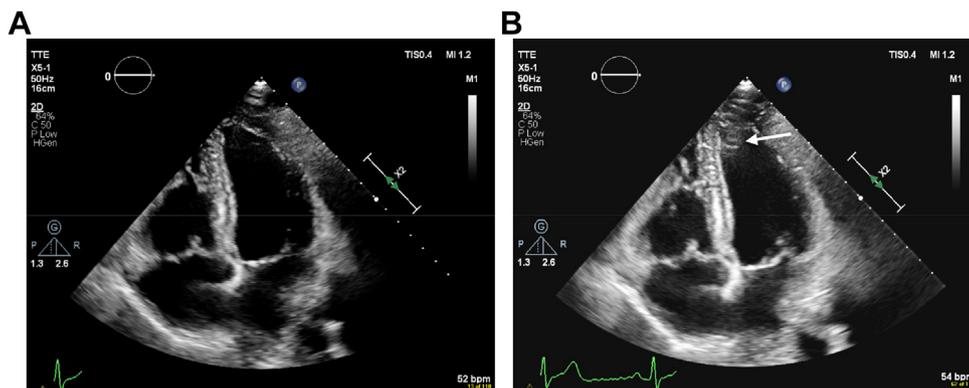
Generation of NFC in a healthy individual. In panel A, a standard apical four-chamber view is shown with clear visualization of the LV apical region without any artifact. When slightly tilting the probe in the intercostal space, a hazy NFC appears (white arrow in panel B).
